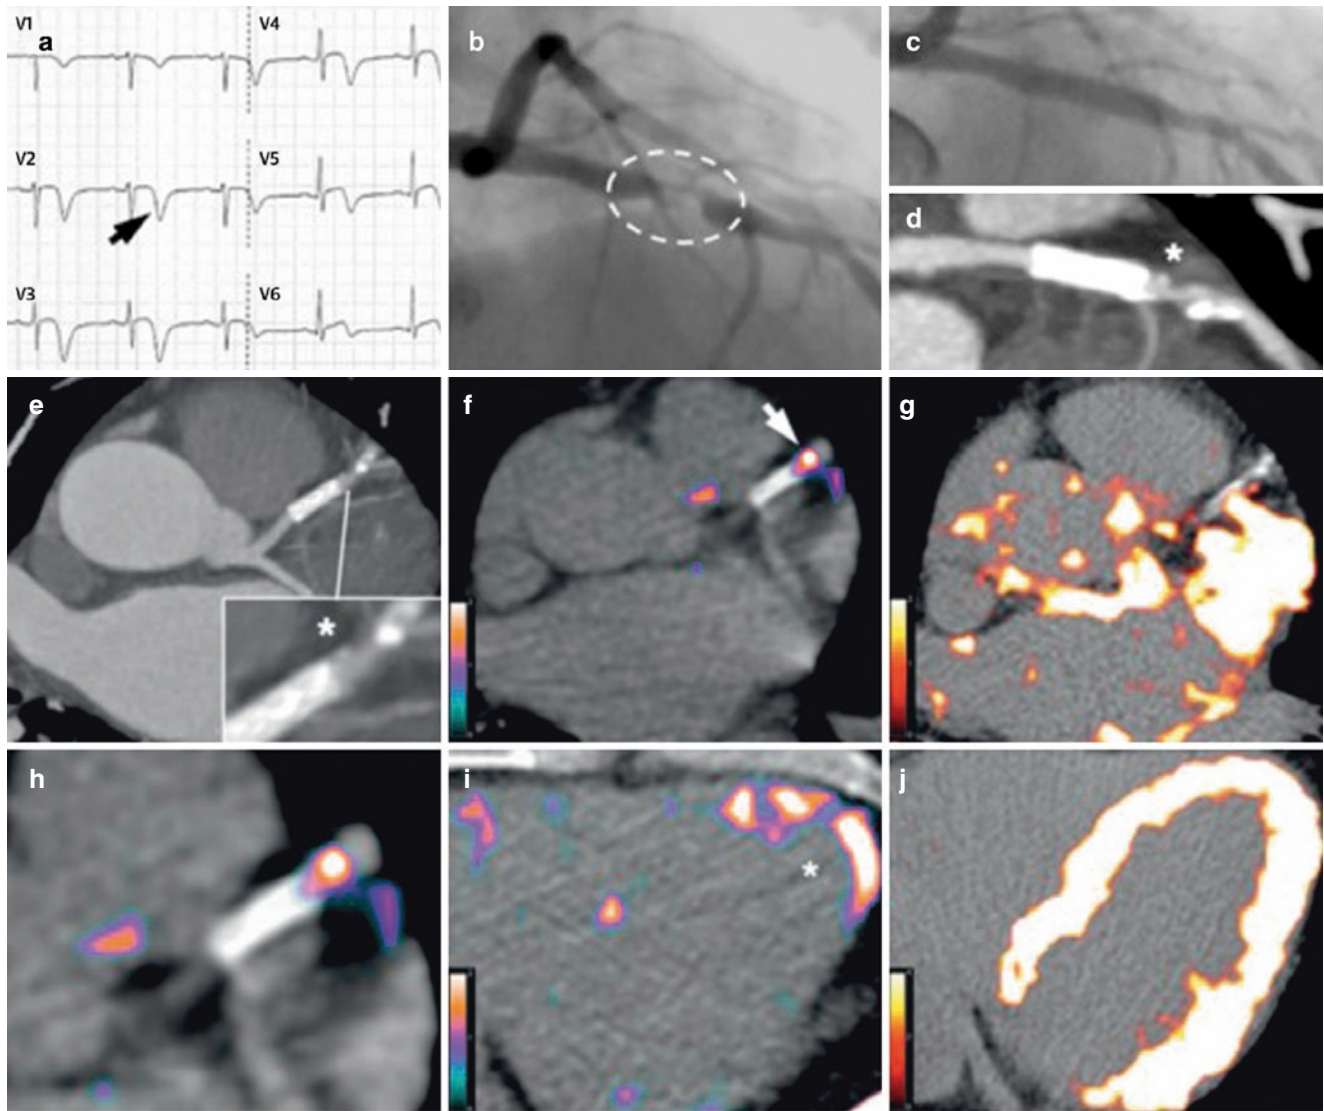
Comparison of coronary PET imaging using gallium-68-labeled DOTATATE (^{68}Ga -DOTATATE) versus FDG, using images from a patient presenting with an acute coronary syndrome (a). Angiography showed a culprit left anterior descending artery lesion (dashed oval) (b). A stent was placed (c), but CT angiography (d and e) showed residual plaque (asterisks) at the distal end of the stent. ^{68}Ga -DOTATATE PET was performed (f, h, i), revealing focal
